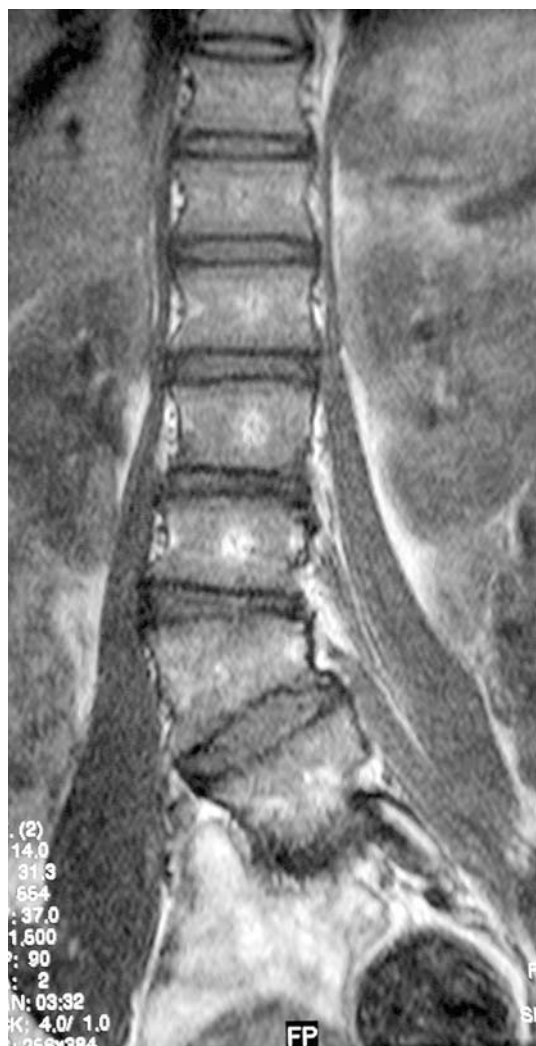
Coronal T1W MRI showing wedging of the L3 vertebra
